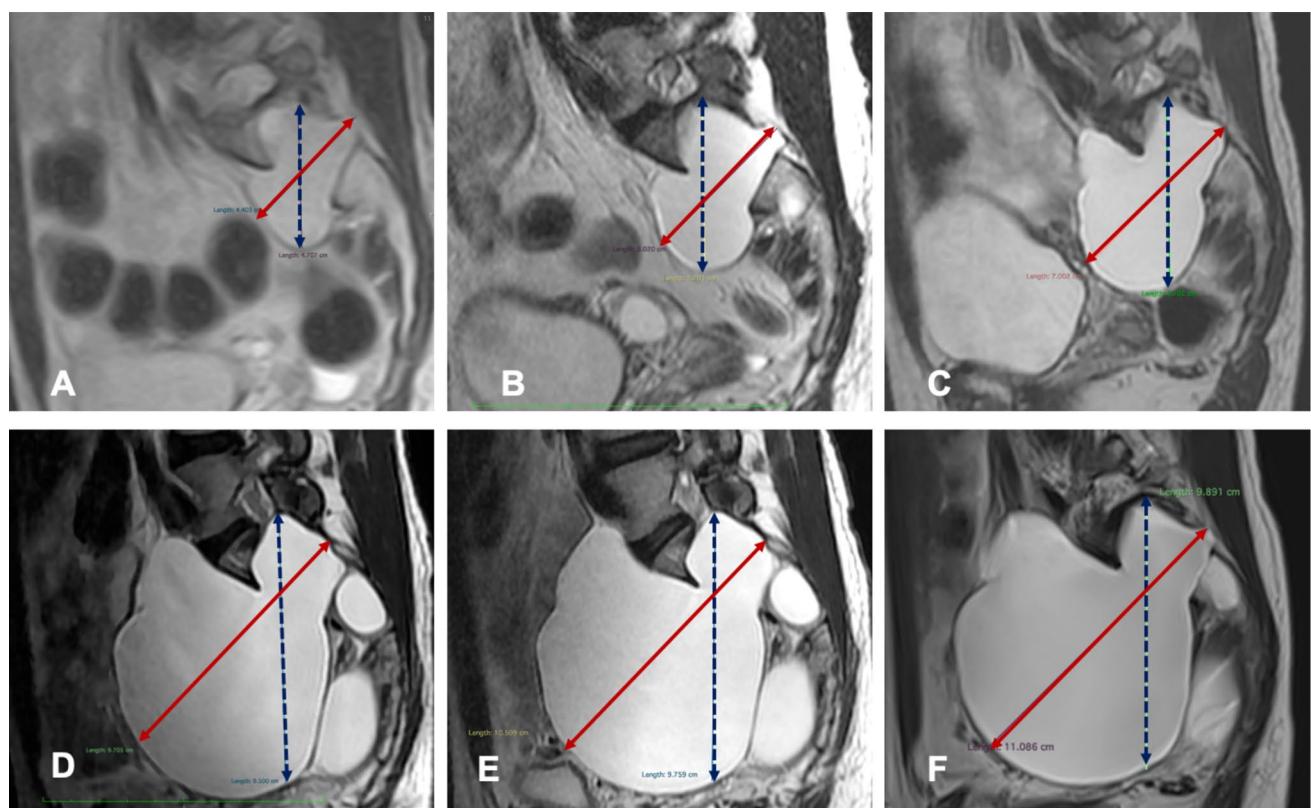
Figure shows the growth of a sacral GTC in twelve years with 6 consecutive sagittal T2 WI of lumbosacral MRI. A-12 years, B-9 years, C-6 years, D-3 years, E-6 months, and F-2 months before the surgery. Cyst clearly grows in years and reaches to an intrapelvic giant mass
